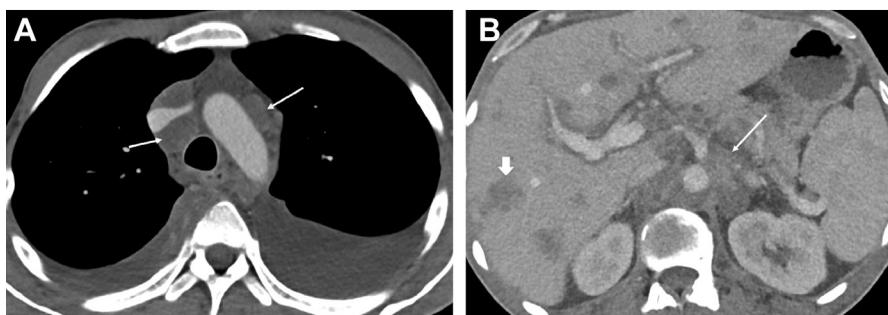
37-year-old man with AIDS and CD4 count of $14/\mu\text{L}$, diagnosed with cutaneous and lymph node Kaposi sarcoma as well as disseminated MAC infection. CT images show (A) mediastinal and abdominal lymphadenopathy (white arrows), biopsy-proven MAC, as well as (B) multiple hepatic lesions, likely Kaposi sarcoma (broad white arrow).
